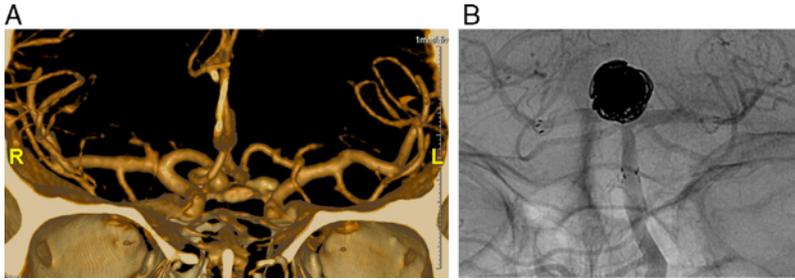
A, Anterior communicating artery aneurysm (CT angiogram 3D reconstruction). B, Stent-assisted coil embolization: Y-shaped stent extending from the basilar artery into bilateral posterior cerebral arteries and coil-packed basilar tip aneurysm. [full color online](#)
